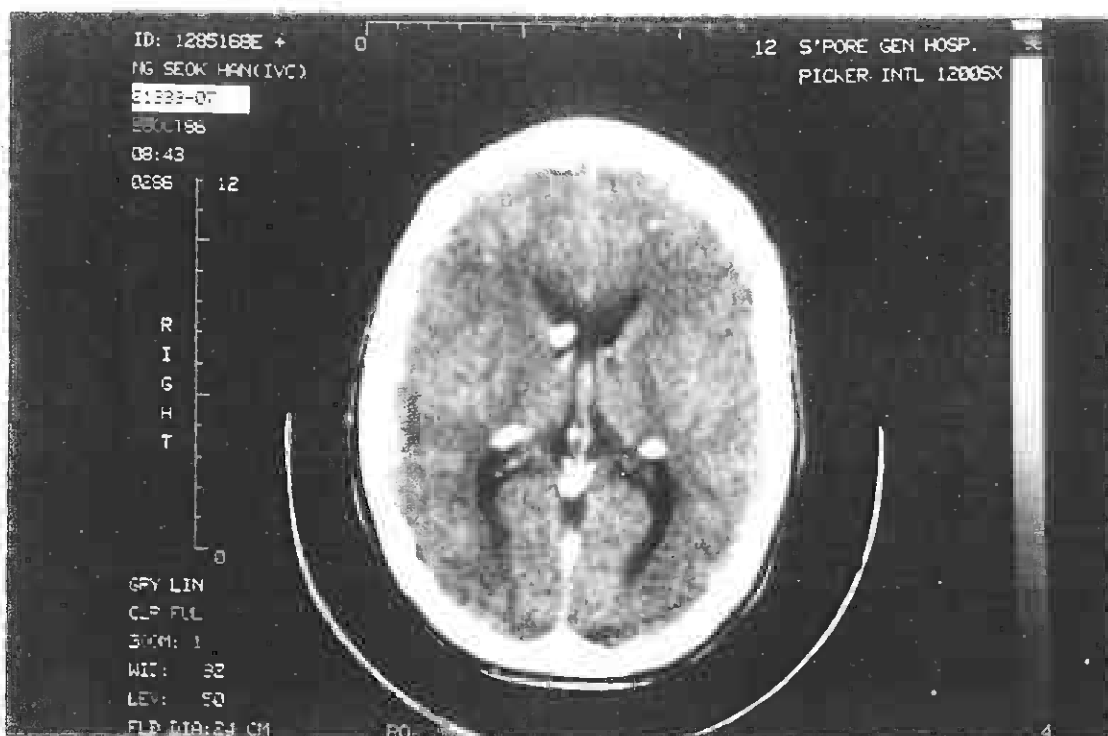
Intracranial calcifications on CT scan
